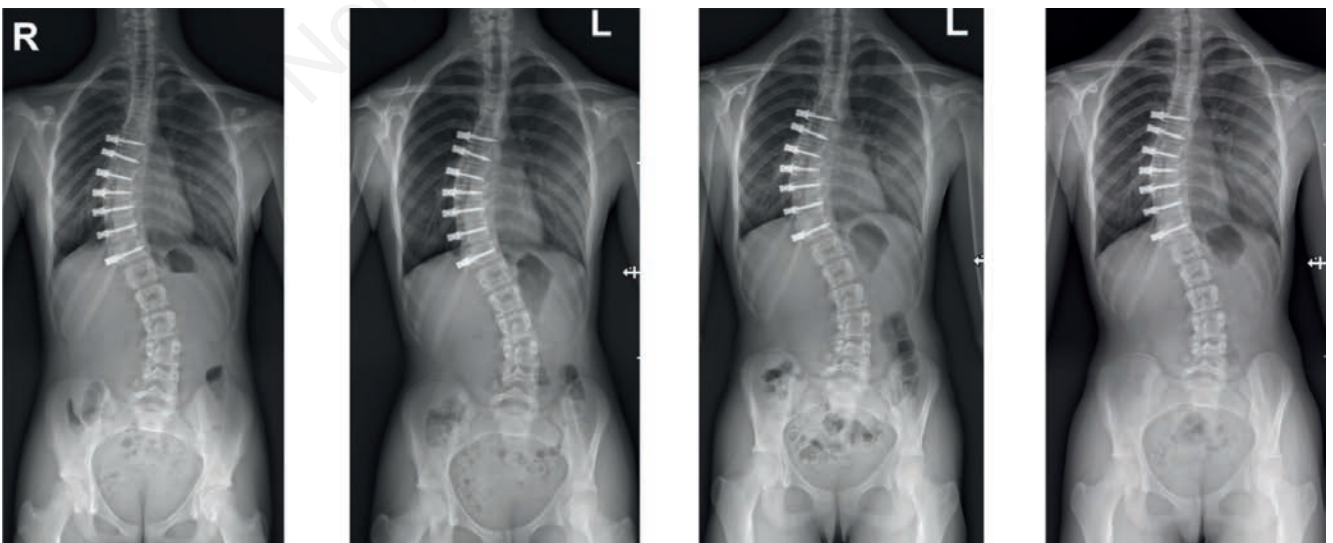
Post-operative X-rays of the same patient in figure showing Cobb angle 32° on postoperative X-rays, 35° six months after surgery, 34° 1 year after surgery and 30° 2 years after surgery.
